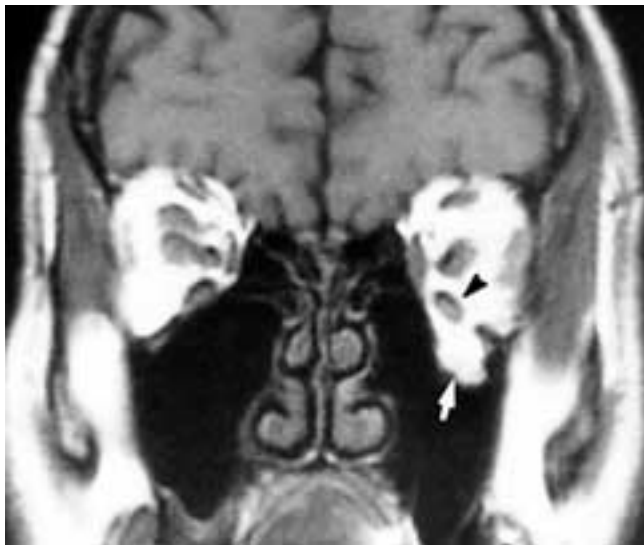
Coronal T1-weighted MR image shows a left blow-out fracture. Fat has herniated into the left antrum (*arrow*), and there is minimal depression of the inferior rectus muscle (*arrowhead*).
